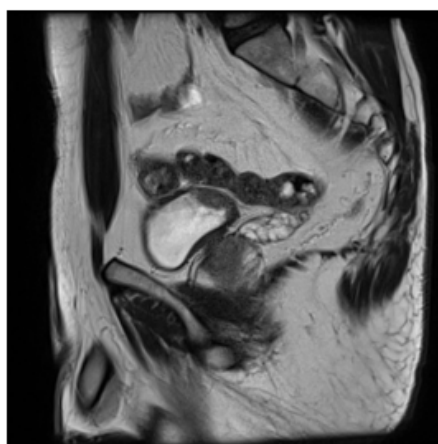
Sagittal MRI section post endoscopic resection.
